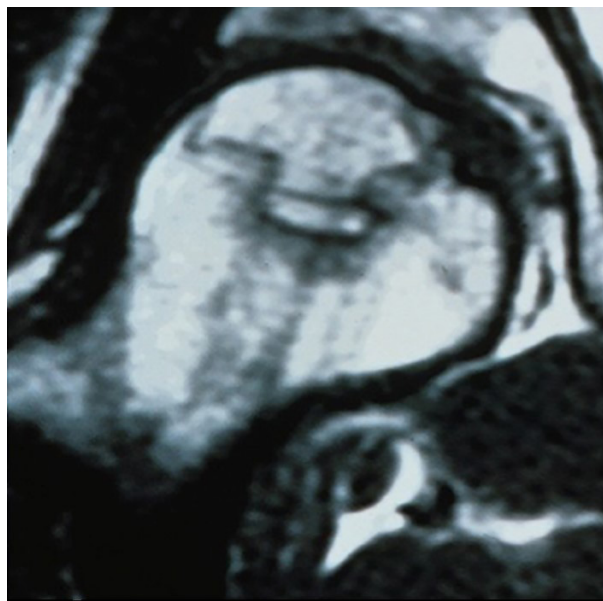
MRI for the diagnosis of FH ON
